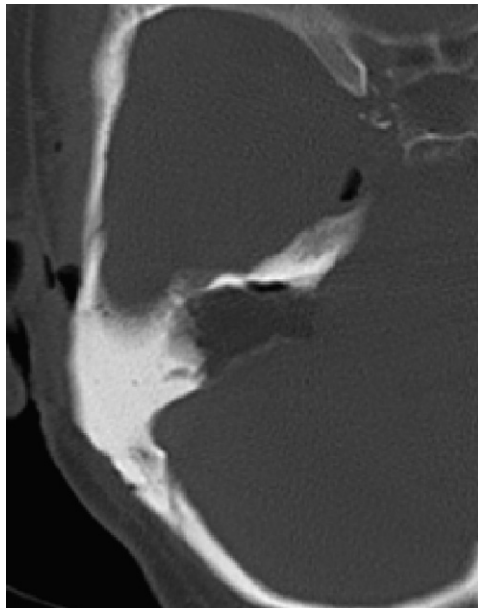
Postoperative CT scan after translabrynthine removal of tumor with abdominal fat medially and hydroxyapatite cement reconstruction of the mastoid defect.
